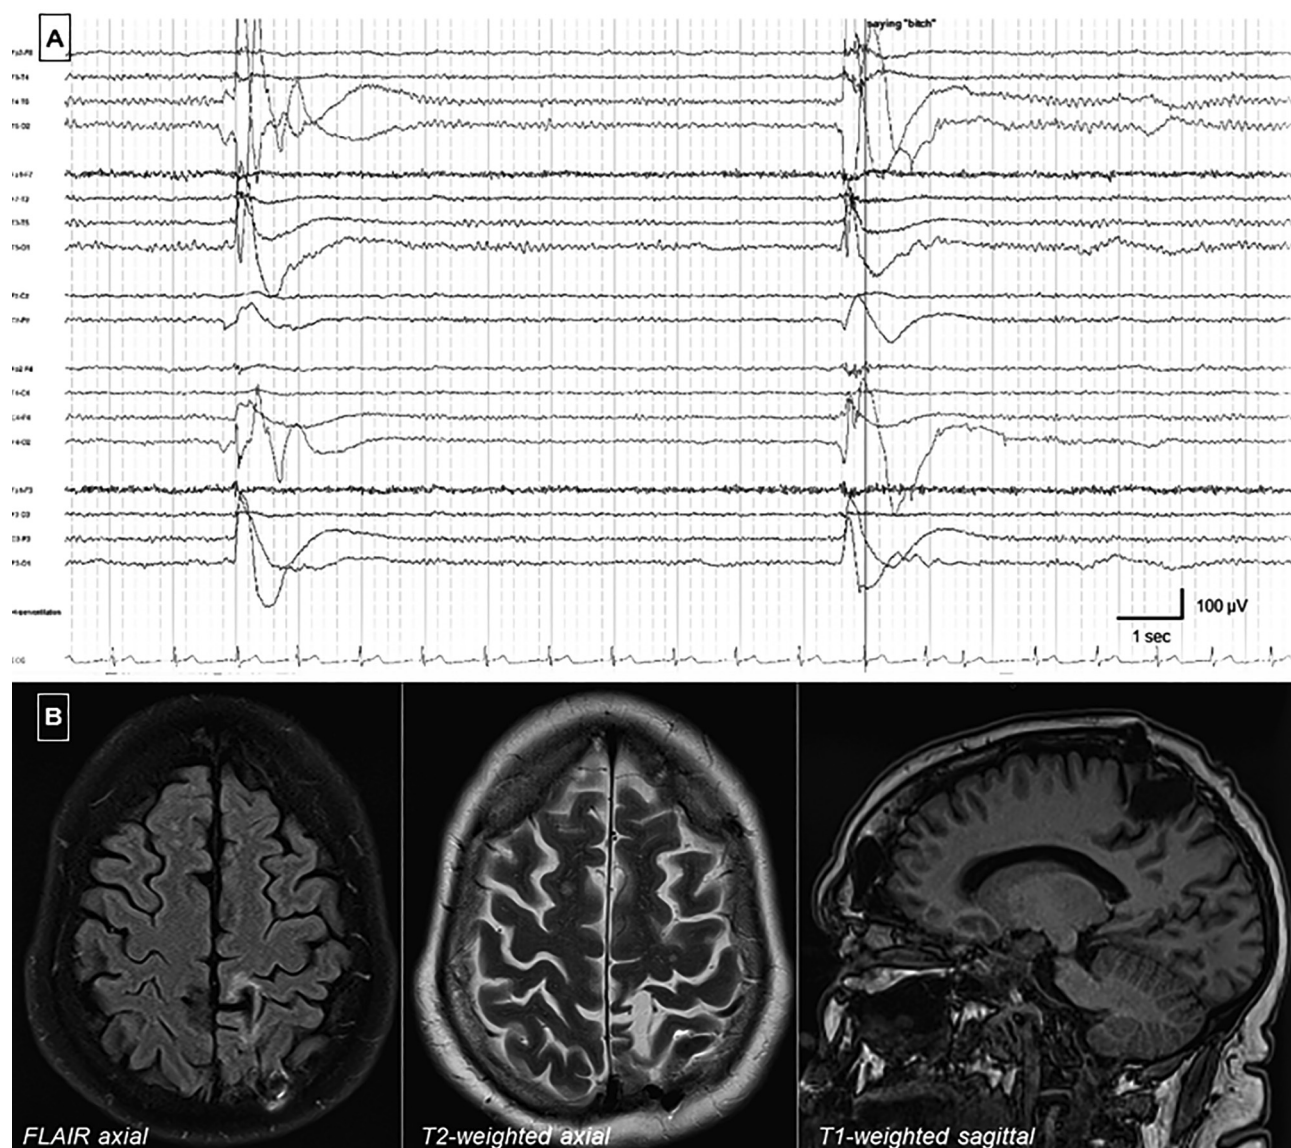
(A) EEG during motor and vocal tic, showing motion artefact with no epileptiform activity. (B) MRI of the brain performed at onset of tic disorder, seven years after head injury, showing focal encephalomalacia in the left parietal lobe.
